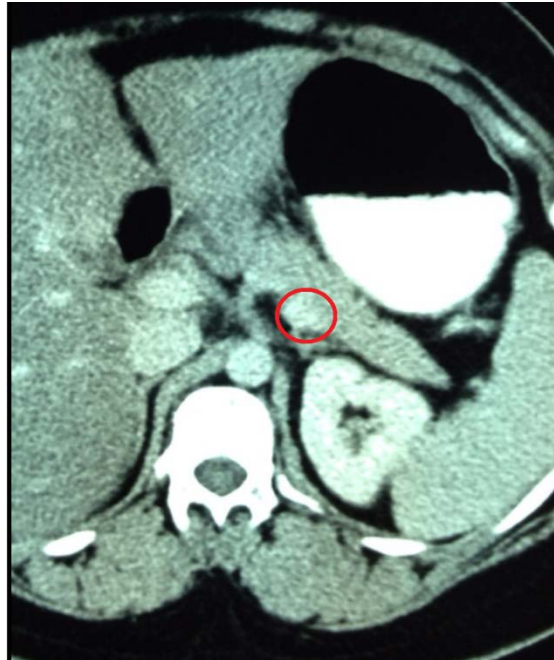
Contrast enhanced CT scan of the abdomen which had suggested the presence of a small vascular lesion (marked by the red circle) within the pancreas; no suggestion of insulinoma was made by the radiologist.
